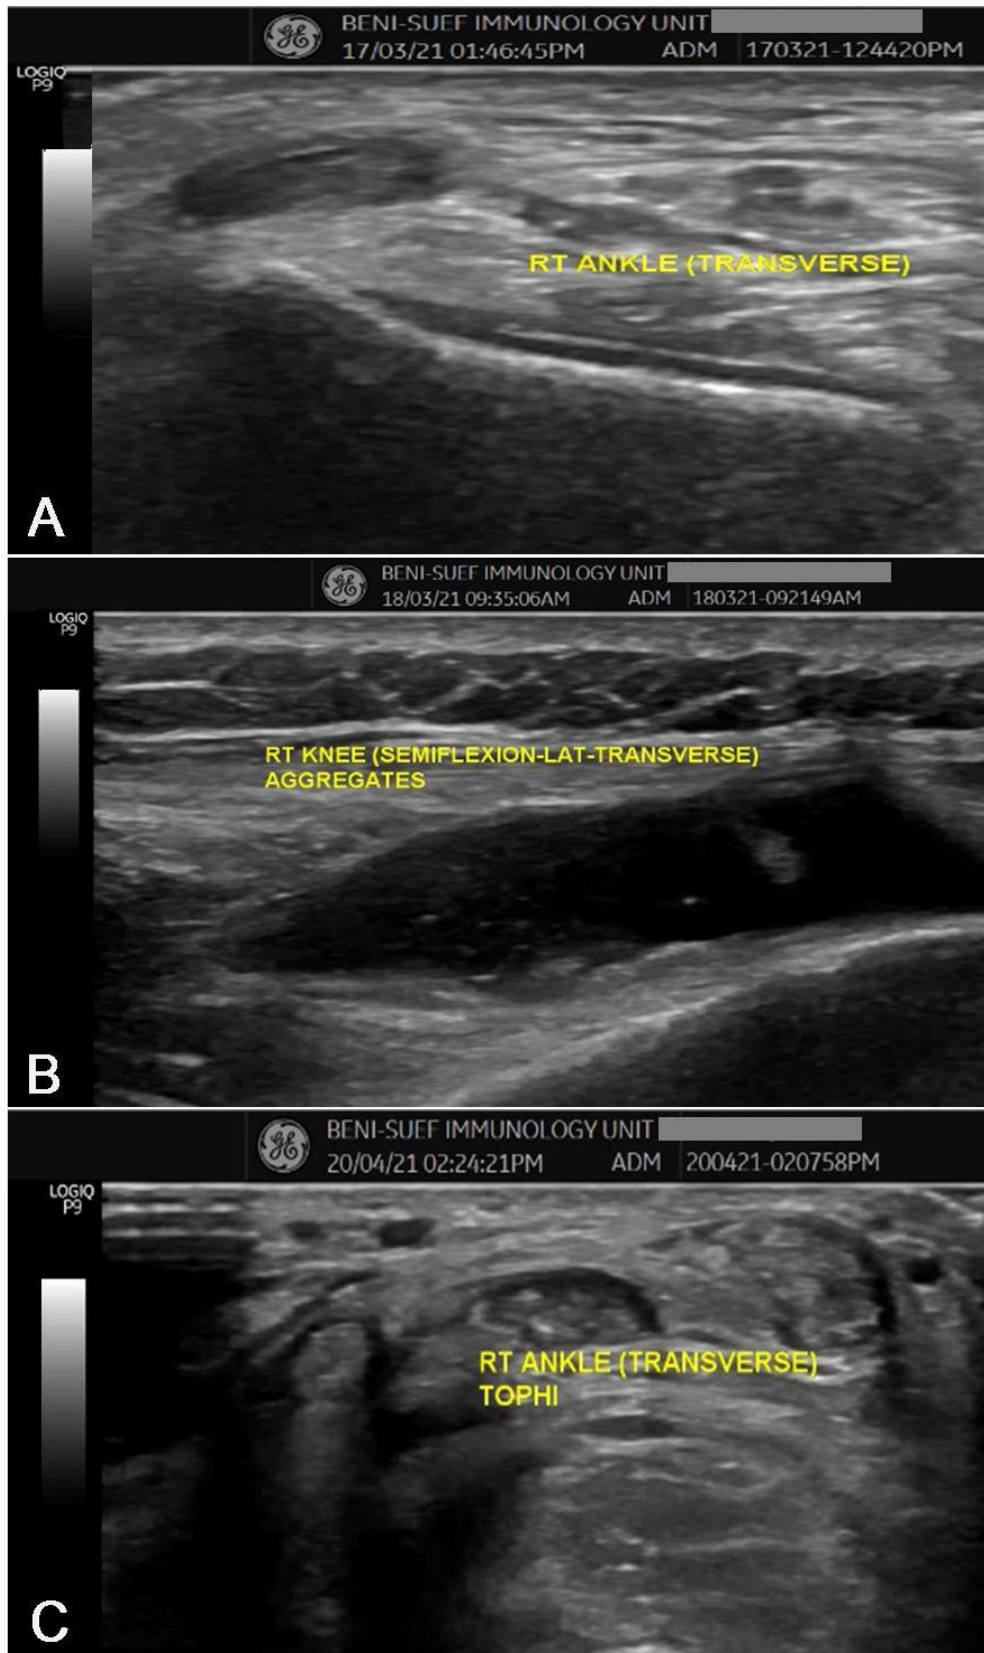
Musculoskeletal ultrasound of different patients in both group where (A) and (C) of asymptomatic hyperuricemic patients while (B) of symptomatic hyperuricemic patients. These joints abnormalities showing (A) Double contour sign (right ankle), (B) aggregates (right knee) and (C) Tophi (right ankle).
